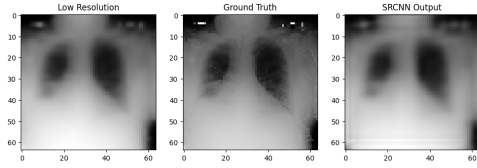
NIH chest X-ray dataset result (Baseline).
